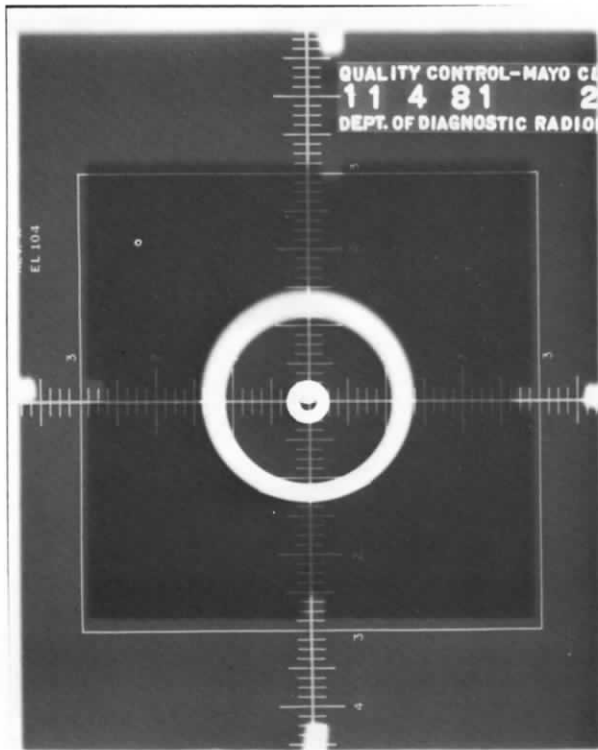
Acceptable x-ray-light field alignment and x-ray beam perpendicularity test results. Left film from tabletop; right film from Bucky tray.
